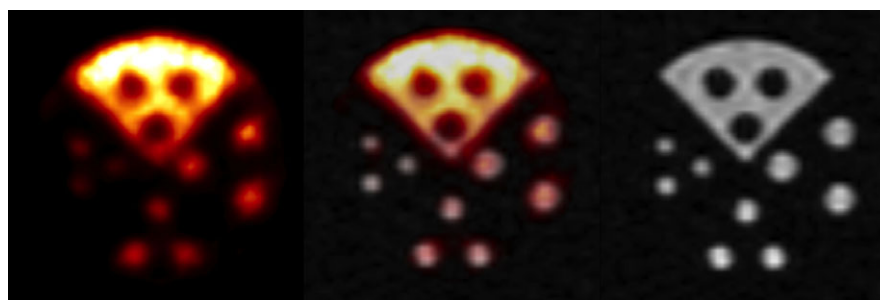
PET/MR image fusion, data acquired simultaneously during GRE sequence. Left: PET image; right: MR image; center: PET/MR fusion. [Color figure can be viewed at wileyonlinelibrary.com]
